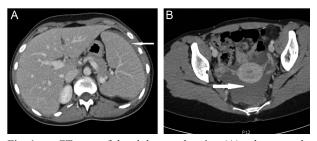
CT scan of the abdomen showing (A) splenomegaly with intracapsular perisplenic hematoma (arrow), (B) hemoperitoneum (arrow).
